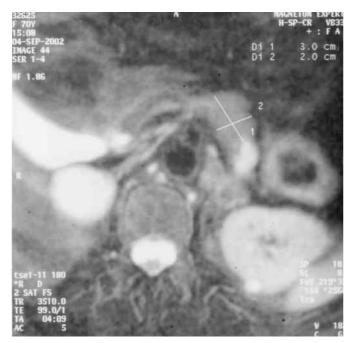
T1-weighted MRI scan of the abdomen after the administration of contrast material, showing a pancreatic tumor (cross lines)
